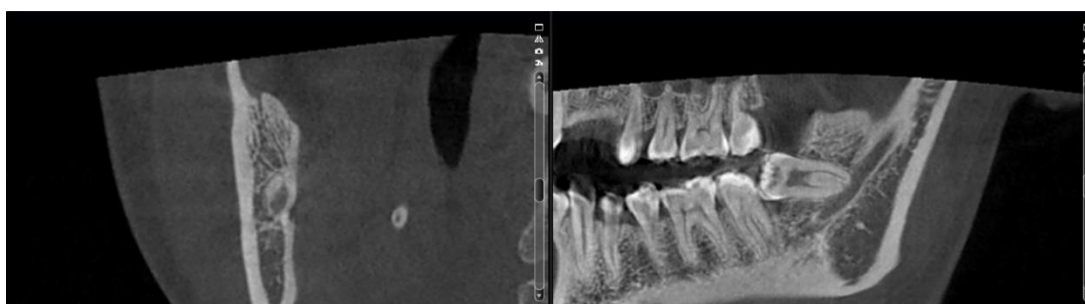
Preoperative CT image, apical pressure on the alveolar neural tube
